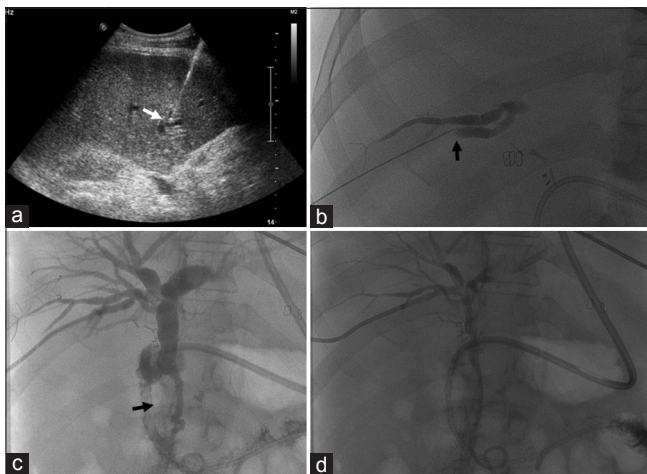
A case of percutaneous biliary drainage after failed endoscopic retrograde cholangiopancreatography and iatrogenic pancreatitis. (a) The puncture of an intrahepatic bile duct under ultrasound guidance (the white arrow indicates the tip of the Chiba needle). Percutaneous cholangiography (b) depicts the biliary tree allowing guidewire insertion (through the Chiba needle, black arrow) and catheterization of the common bile duct and duodenum (c). Intrahepatic bile ducts and the common bile duct are dilated with narrowing of the intrapancreatic bile duct (black arrow in c). (d) Successful biliary decompression
